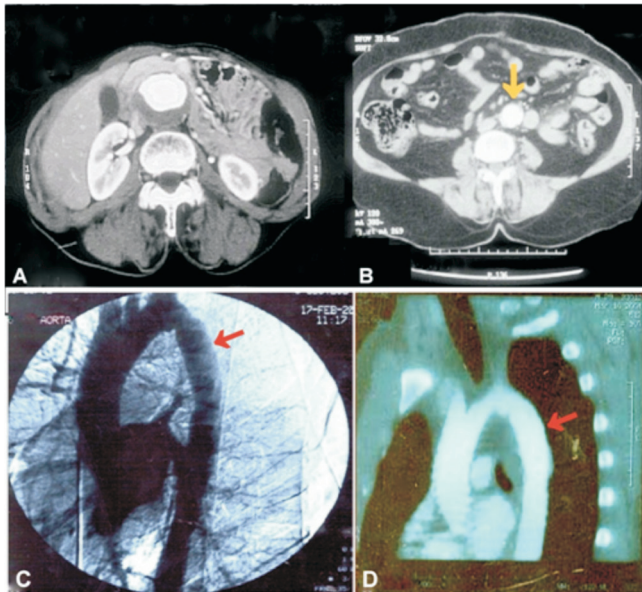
Contrast-enhanced abdominal CT scan axial section of a symptomatic patient in phase I clinical trial showing an infra-renal abdominal aortic aneurysm (A). Abdominal contrast enhanced CT scan of the same patient taken 8 years after repair showing intact and patent test vascular graft (yellow arrow) (B). Follow-up imaging of an adult patient with coarctation of aorta treated by interposition grafting with test vascular graft as part of phase I trial. Digital subtraction angiogram (DSA) at 1 year (C) and CT angiogram at 6 years (D) showing preserved and patent graft (red arrows).
